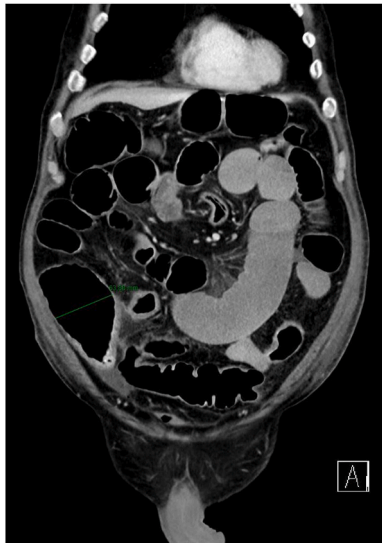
Repeat CT on Day 4 of admission, highlighting ongoing resolution of pseudo-obstruction. Complete clinical resolution would require a further three days.
